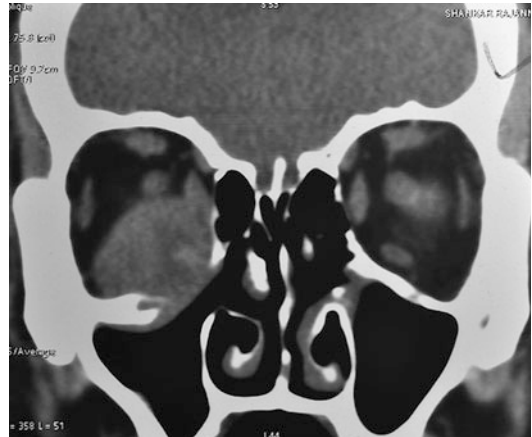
Coronal CT scan showing a large mass in the inferior quadrant with indistinct inferior rectus and orbital floor erosion
